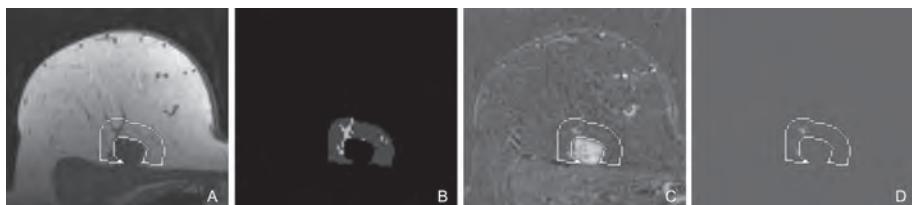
Axial MRI slices through invasive ductal carcinoma with surrounding E-DCIS in left breast. A. Precontrast T1-weighted non-fat-suppressed image, inner white line indicates tumor border and outer white line indicates automatically extended margin of 10 mm. B. Segmentation of 10-mm margin into FGT (white) and adipose tissue (gray). The proportion of FGT is high. C. Subtraction of the first postcontrast scan minus the precontrast scan. D. The relative signal increase between the precontrast and first postcontrast scan in the 10-mm extended margin around the MRI-visible lesion.
